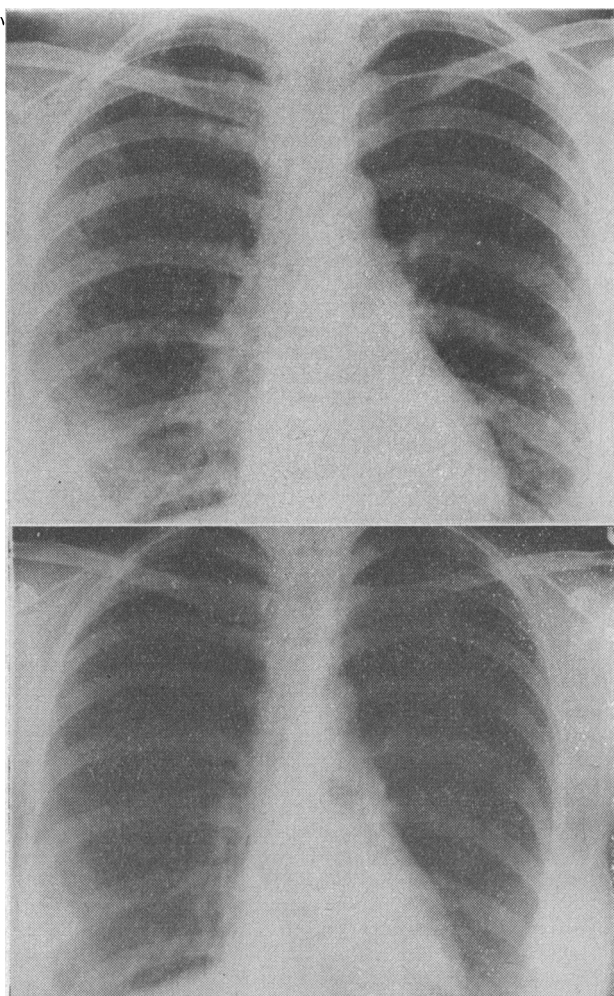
Case 4. Top: Chest x-ray film taken on July 30, 1959, showing multiple small metastases in both lung fields. Bottom: Chest x-ray film taken on September 10, showing radiological clearing after six weeks' treatment.
